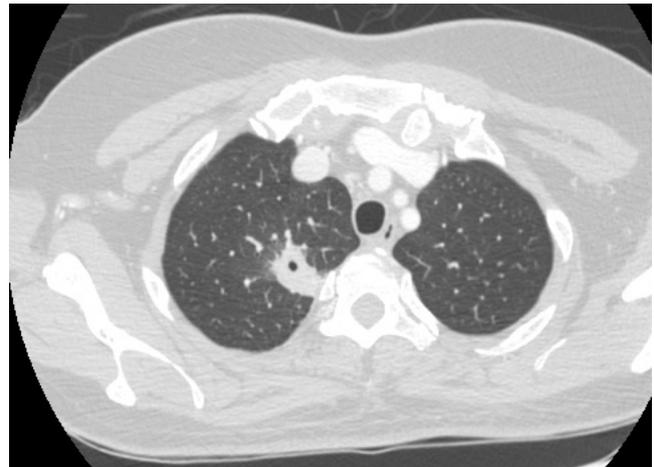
A 53-year-old male with underlying acute myeloblastic leukemia and neutrophils 1,159 cells/mm³ with history of fever and cough. Axial thoracic CT scan demonstrated a lucent area within nodule that represented central cavity at right upper lobe. The final diagnosis was invasive pulmonary aspergillosis.
